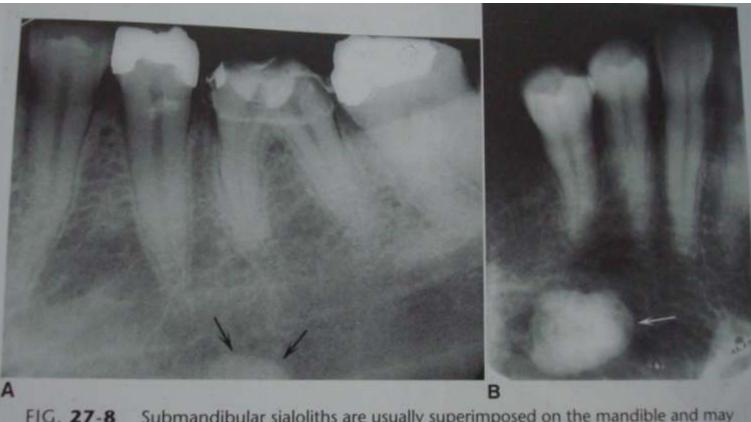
Submandibular sialoliths are usually superimposed on the mandible and may be difficult to differentiate from a dense bone island without an occlusal film. A, Periapical film just reveals the superior aspect of a sialolith. B, The sialolith is superimposed over the anterior aspect of the mandible.
